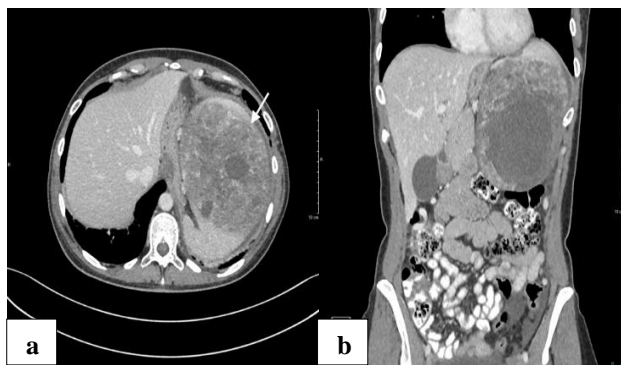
Contrast-enhanced computed tomography scan (a) axial view and (b) coronal view. Significant splenomegaly (17.5×15×9 cm) with solid components and hypodense cystic areas consistent with peliosis.
